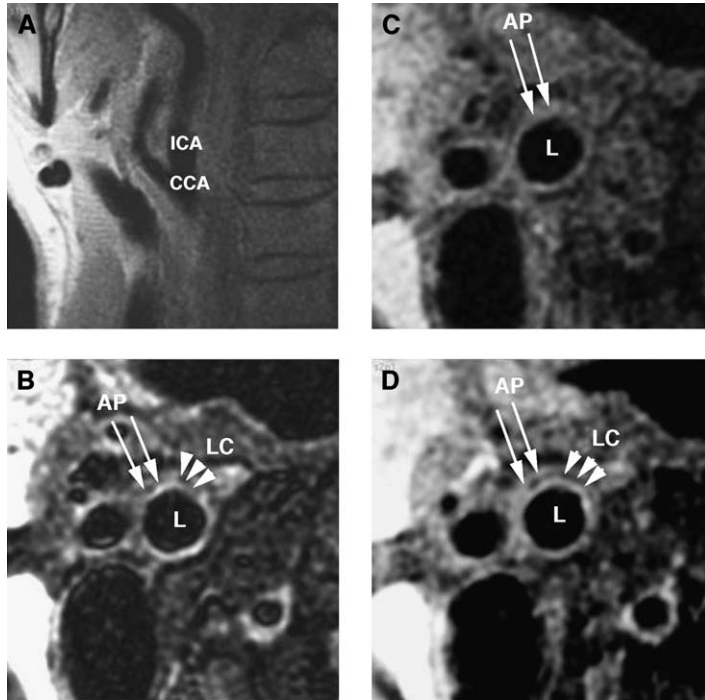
High-resolution MR images of the right carotid artery of a 72-year-old man with advanced atherosclerosis. (A) Oblique proton-density image through the proximal internal and external carotid arteries. This image was used to prescribe subsequent images. CCA, common carotid artery ICA, internal carotid artery. (B) T2-weighted precontrast, (C) T1-weighted precontrast and (D) T1-weighted postcontrast FSE images of the right internal carotid artery demonstrating arterial wall remodeling caused by atherosclerotic plaque (AP). Note the lipid core (LC) within the atherosclerotic plaque on T2-weighted and postcontrast T1-weighted images. L, lumen.
